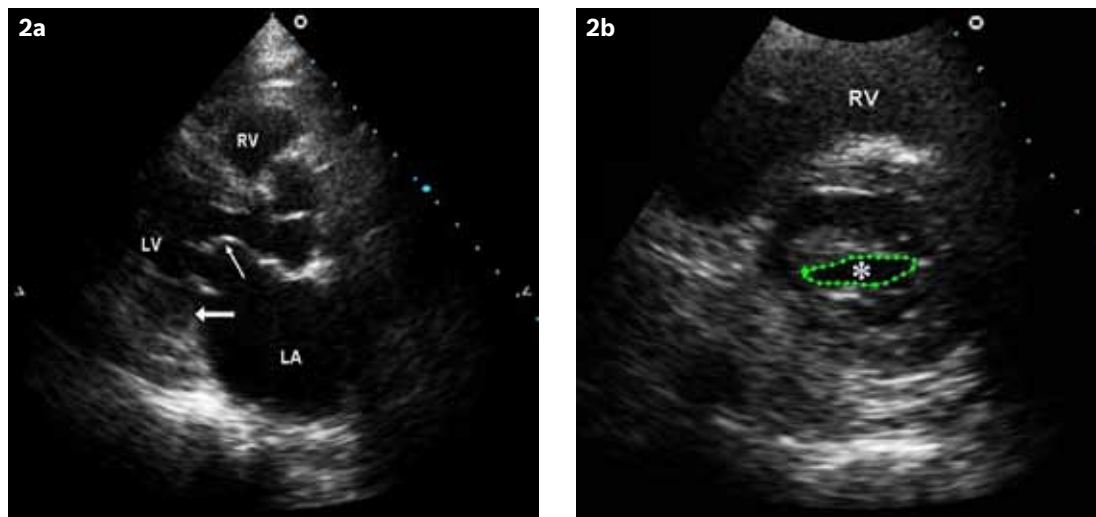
(a) Echocardiogram in the parasternal long axis view shows a calcified mitral valve. There is restricted opening and closing of the posterior mitral valve leaflet (thick arrow), as well as doming of the anterior mitral valve leaflet (thin arrow); (b) At diastole, the mitral valve opening is markedly reduced (outlined and labeled with an asterisk). RV: right ventricle; LV: left ventricle; LA: left atrium
